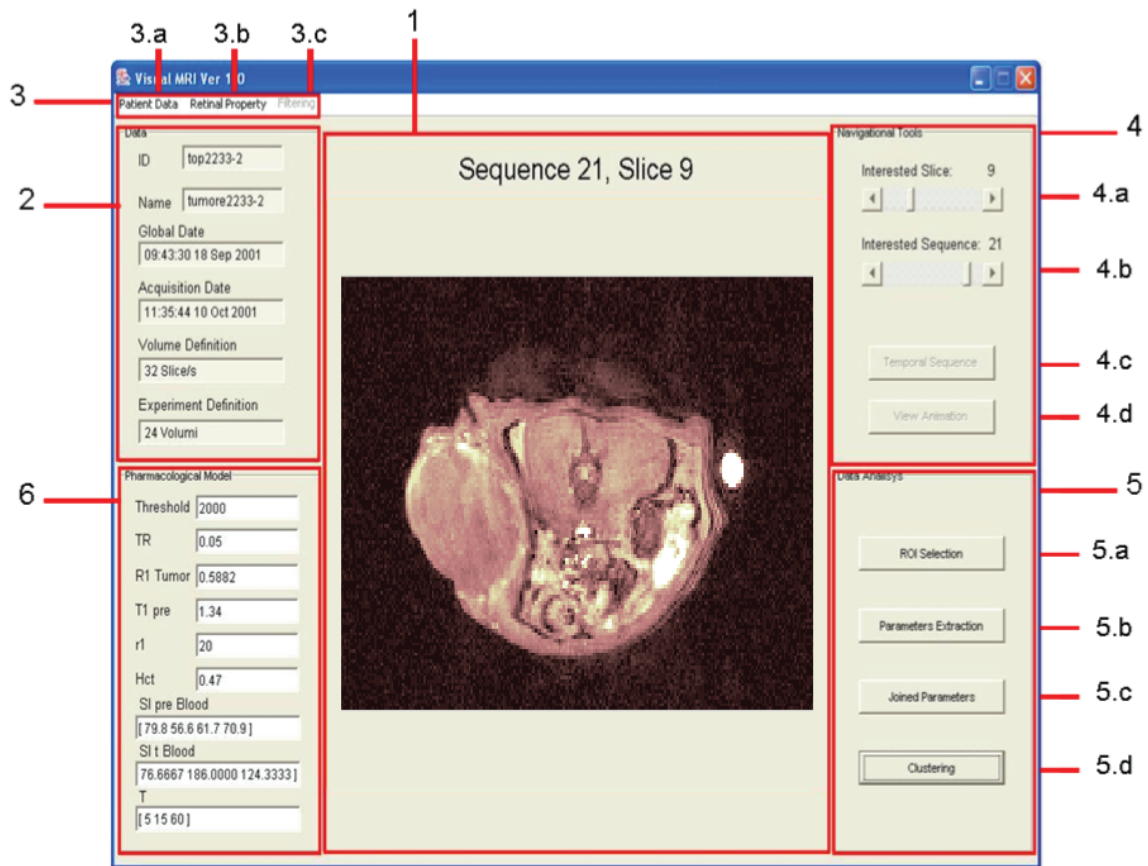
Main interface of *Visual MRI*: the main areas of the interface are enumerated.
